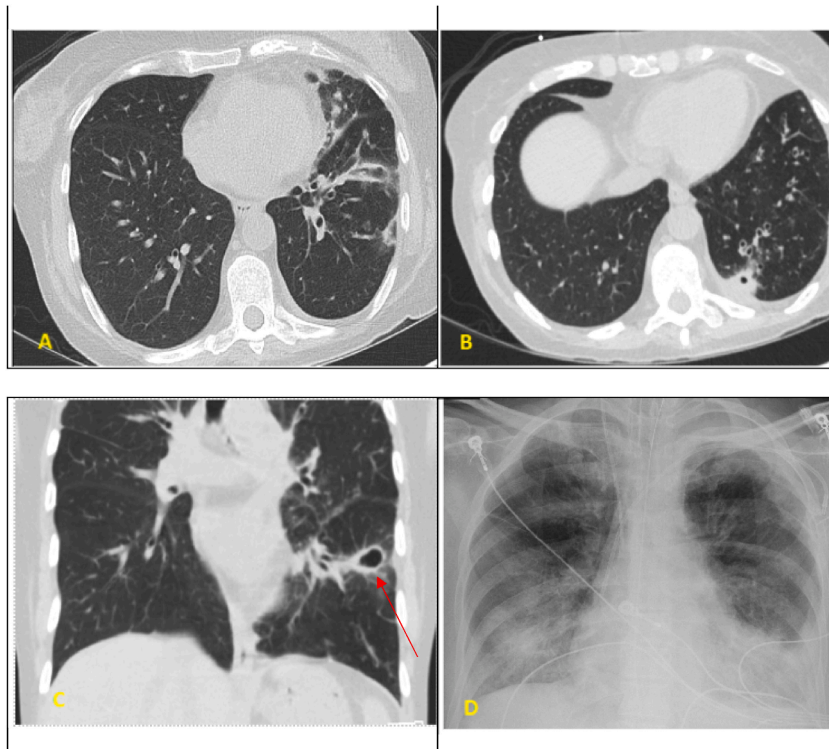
Imaging from *Scedosporium prolificans* infection. Left lower lobe and lingula cavitary lesion seen in radiographic imaging.
